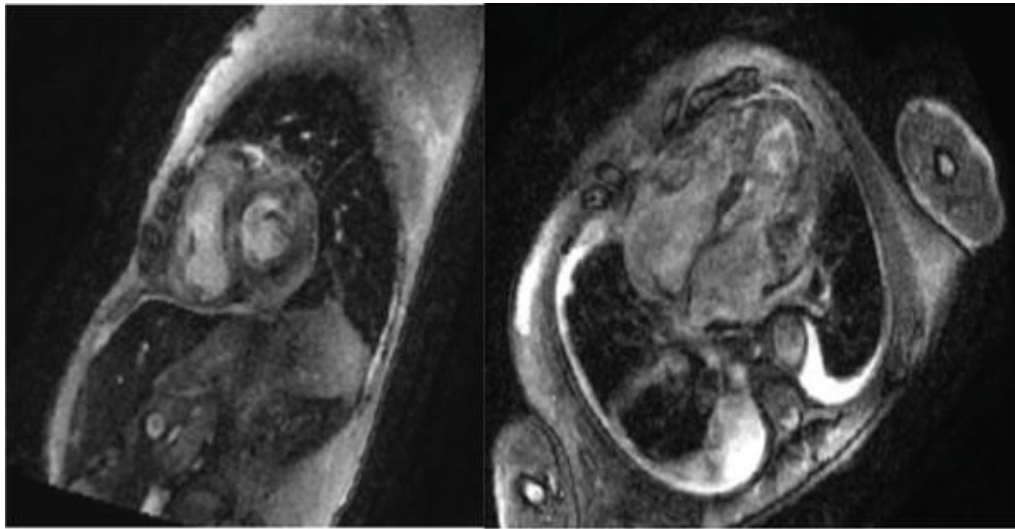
MRI images: short axis 2D myocardial delayed enhancement (left) and four-chamber 2D myocardial delayed enhancement (right): diffuse, inhomogeneous late gadolinium enhancement, suggestive of cardiac amyloidosis.
